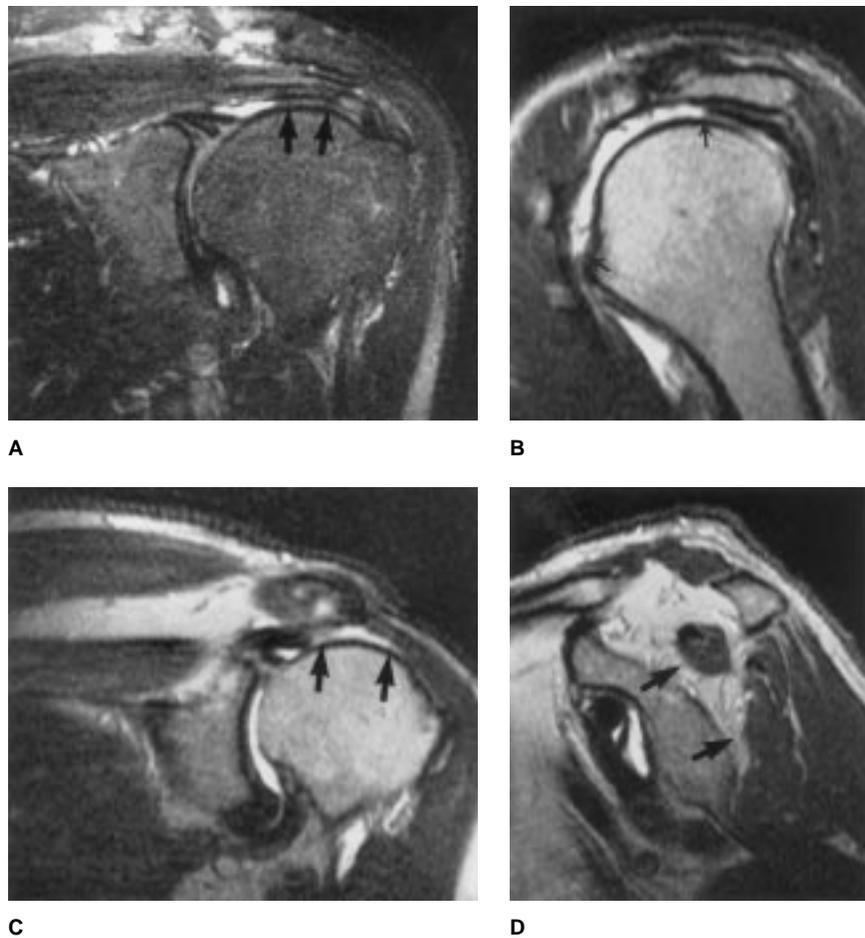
In the postoperative setting, MR imaging criteria for rotator cuff tears must be more stringent. A, Isolated abnormal signal intensity may have no clinical relevance and should be interpreted with caution. The size of a recurrent defect can be quantitated in both the anteroposterior direction (B) and the medial-lateral direction (C). The presence of a tendon signal defect traversed by synovial fluid is indicative of a recurrent defect. D, Atrophy of individual muscles can be assessed.
